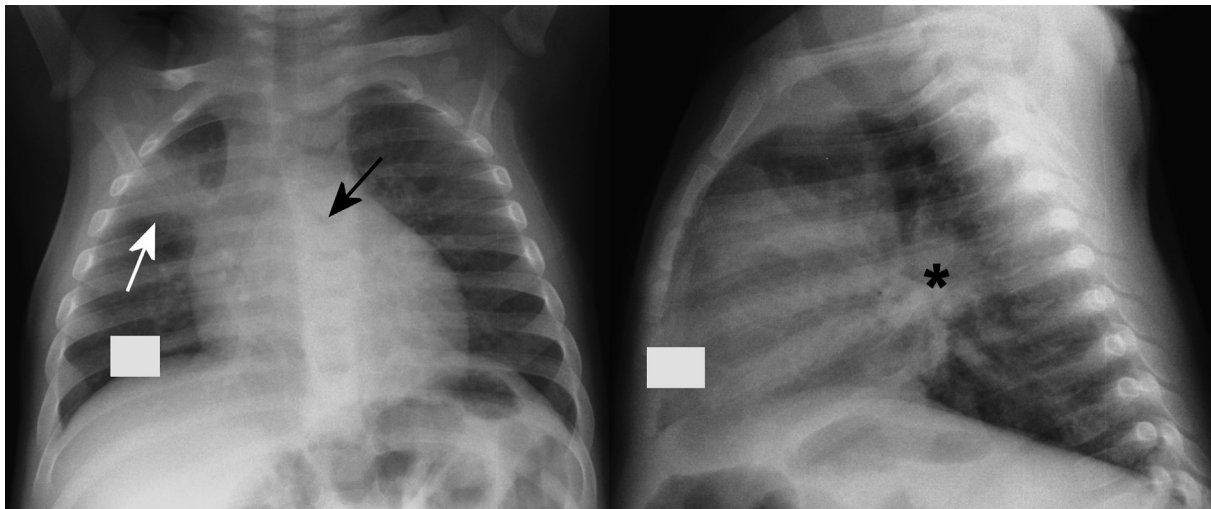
Frontal and lateral chest radiographs of an 8-month-old malnourished female patient with confirmed TB, who was HIV-negative, demonstrating right upper lobe airspace consolidation (white arrow) and perihilar lymphadenopathy (asterisk) causing left main bronchus compression (black arrow).
